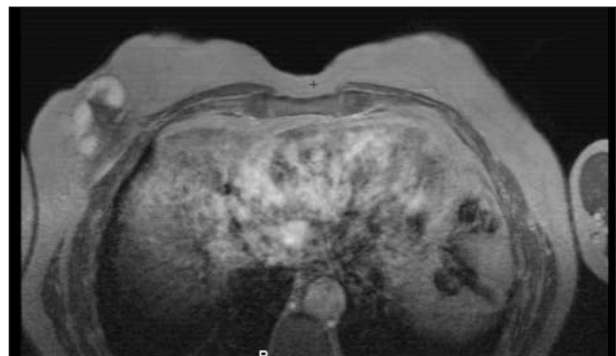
Transverse MRI 2
